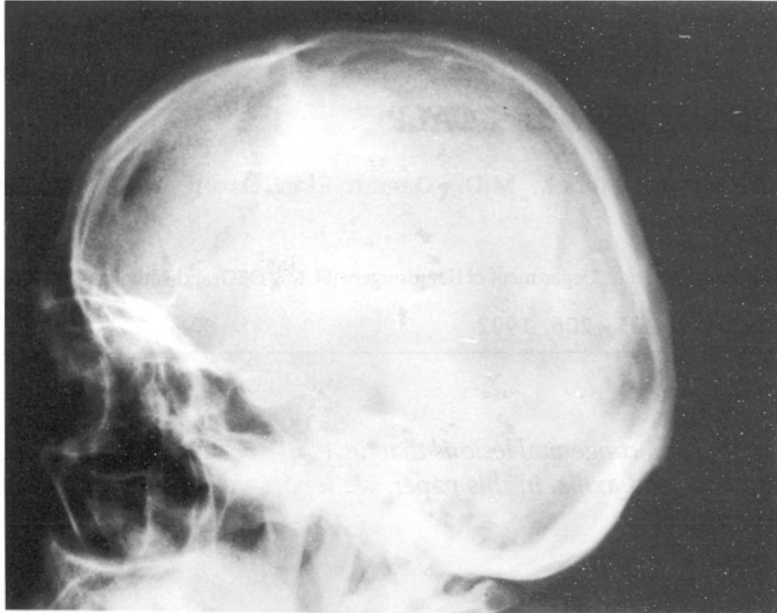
Lateral plain x-ray radiolucent area in the frontal region.
